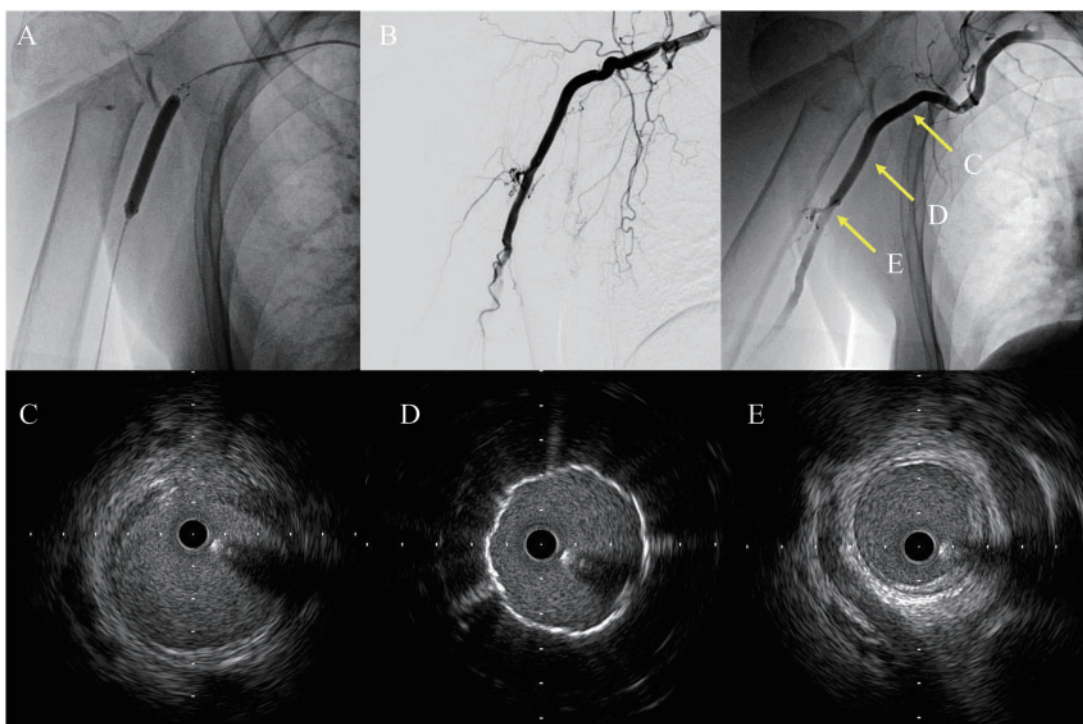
Stent graft placement (A) and subclavian injection after graft placement (B). Intravascular ultrasonography images of the normal axillary artery (C), stent graft implanted lesion (D), and normal brachial artery (E).
